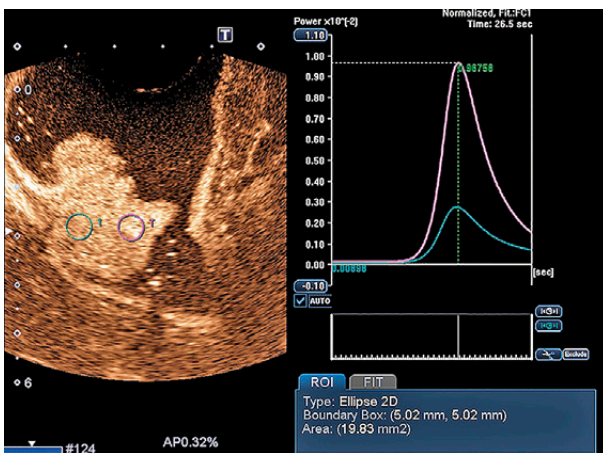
Methods of placing the region of interest (ROI) in the rectal lesion and the time-intensity curve (TIC) of the contrast-enhanced ultrasound (CEUS) image. Left: CEUS imaging at peak phase. Two ROIs were placed in the rectal lesion: the maximum enhancement ROI (purple) and minimum enhancement ROI (green); Right: TICs were generated from two ROIs.
